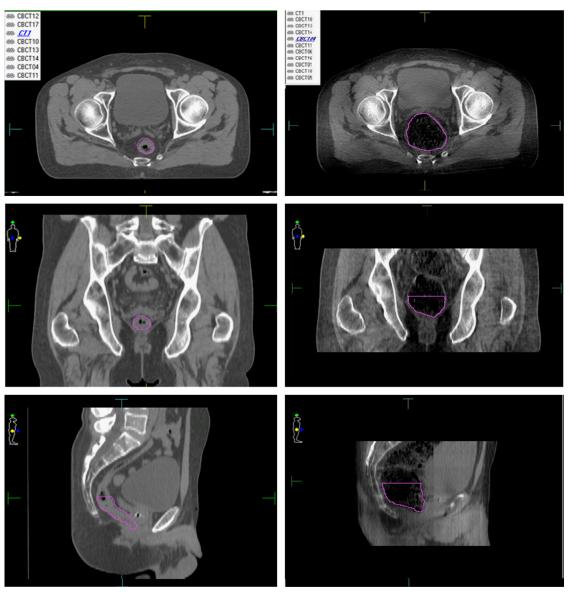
Rectum volume variation between planned CT and CBCT acquired on fourth fraction. (Color version of figure is available online.)
